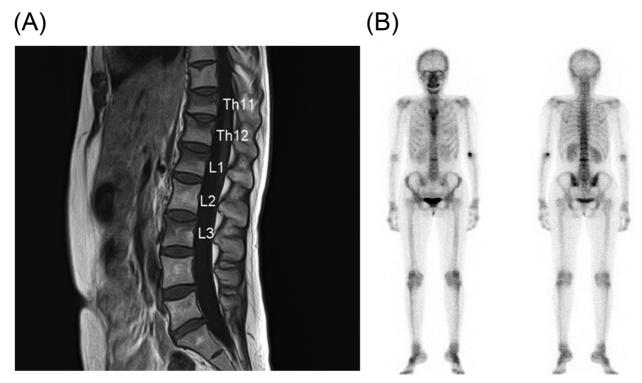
Imaging of the vertebral fractures. (A) T1-weighted magnetic resonance imaging showing the presence of compression fractures at Th11, Th12, L1, L2, and L3. (B) Bone scintigram showing the multiple abnormal fractures in the vertebral columns.
